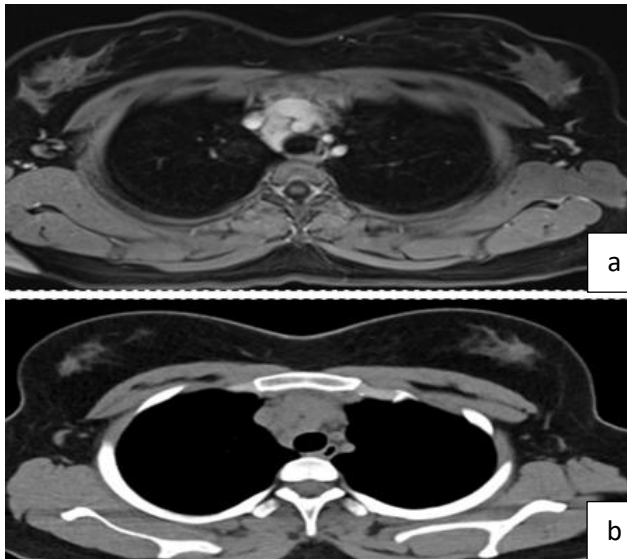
(a and b): Cardiac MRI pictures.
